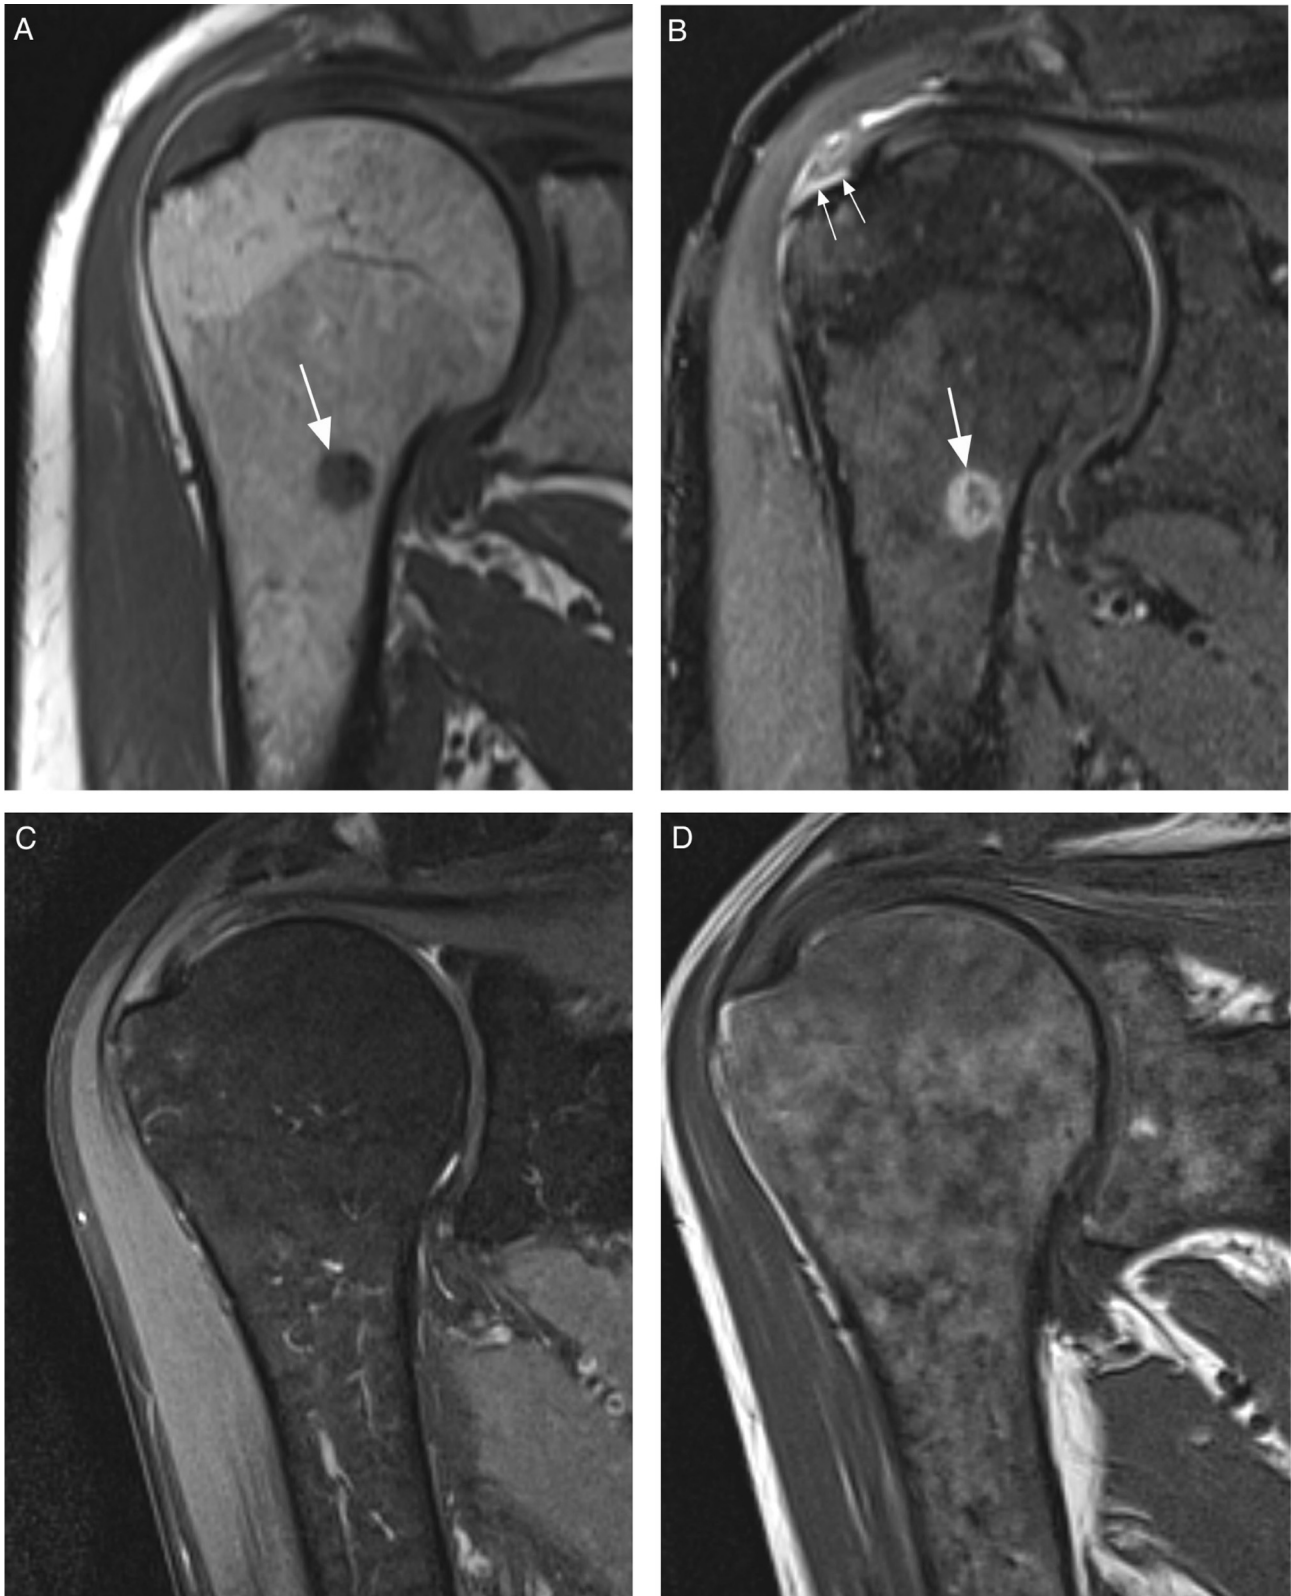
Incidental osseous findings relevant for eligibility and safety but undetectable by X-ray. A. Incident painful shoulder. T1-weighted coronal MR image shows well-circumscribed hypointense lesion in the metaphyseal humeral shaft (arrow) in a patient with history of breast cancer. Finding likely not responsible for pain as there is concomitant supraspinatus tendon pathology. B. Corresponding proton density-weighted fat suppressed image depicts finding as hyperintense lesion (large arrow). Lesion is suspicious of metastasis, which was confirmed by increase in size in a short interval after 3 months. Note that there is an undersurface articular-sided partial supraspinatus tear close to the tendon attachment (small arrows). C. Normal signal intensity of bone marrow is shown on coronal fat suppressed proton-density-weighted image in this example. D. However, corresponding T1-weighted MR image exhibits marked diffuse hypointensity consistent with marrow infiltration. A diagnosis of acute lymphatic leukemia was established shortly after. Sensitivity of T1-weighted images for marrow assessment is exemplified in this image.
